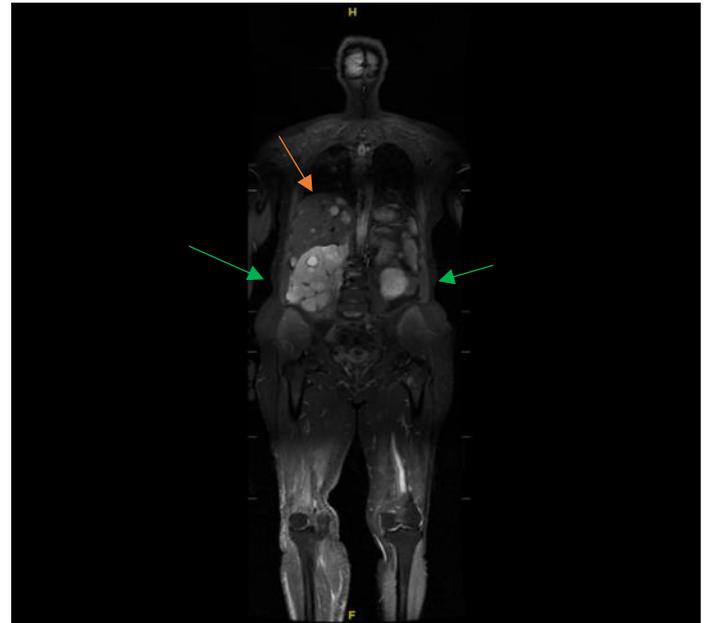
WB-MRI, fat-suppressed T2-weighted sequence coronal section, 4 metastases in the liver parenchyma (orange arrows), metastatic implants in the abdomen (green arrows).
